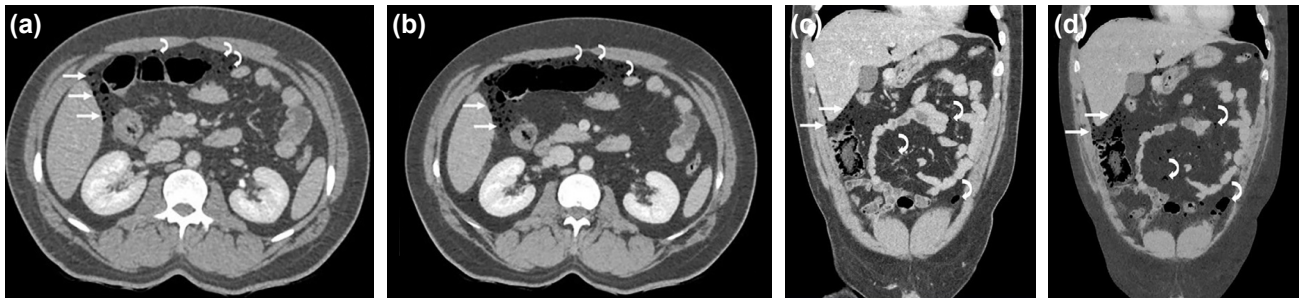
Axial (a) axial reformatted MinIP (b), coronal (c), and coronal reformatted MinIP (d) contrast-enhanced abdominal CT showed free air bubbles in the perihepatic (long white arrows) and perisplenic (dashed white arrow) regions and in fatty tissue between intestinal segments (curved white arrows).
